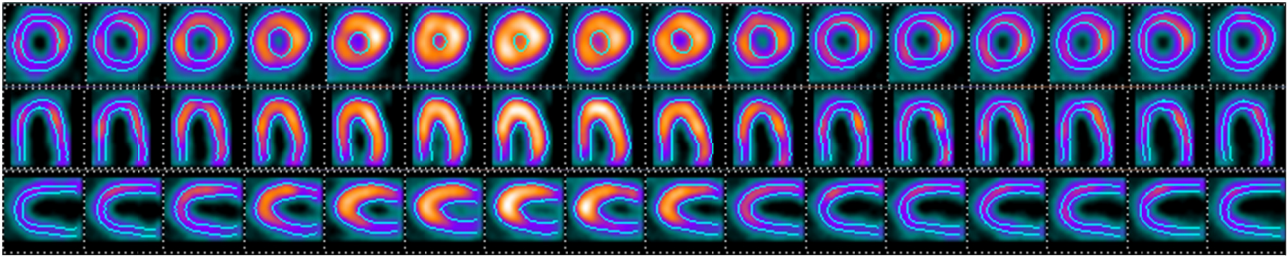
Left ventricle segmentation in gated SPECT.
